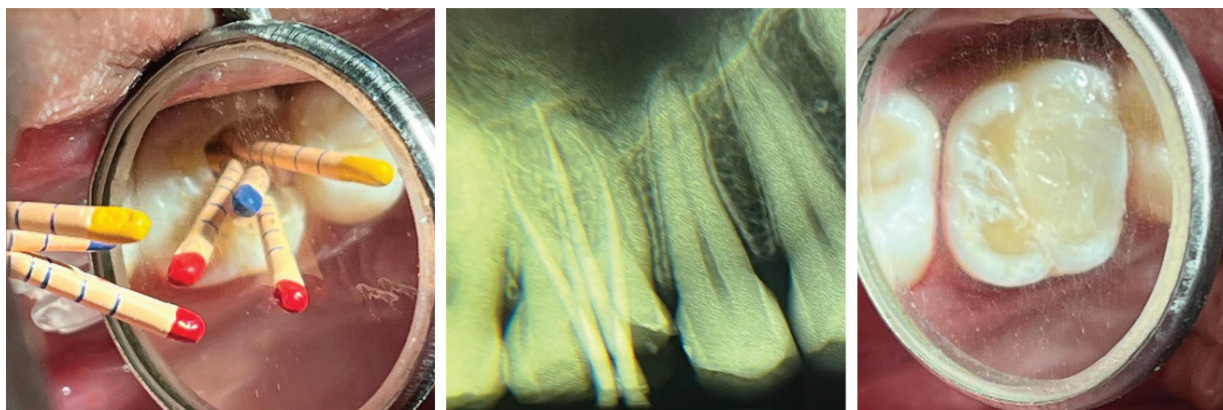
Clinical and radiographic photograph showing the completed treatment in #16
